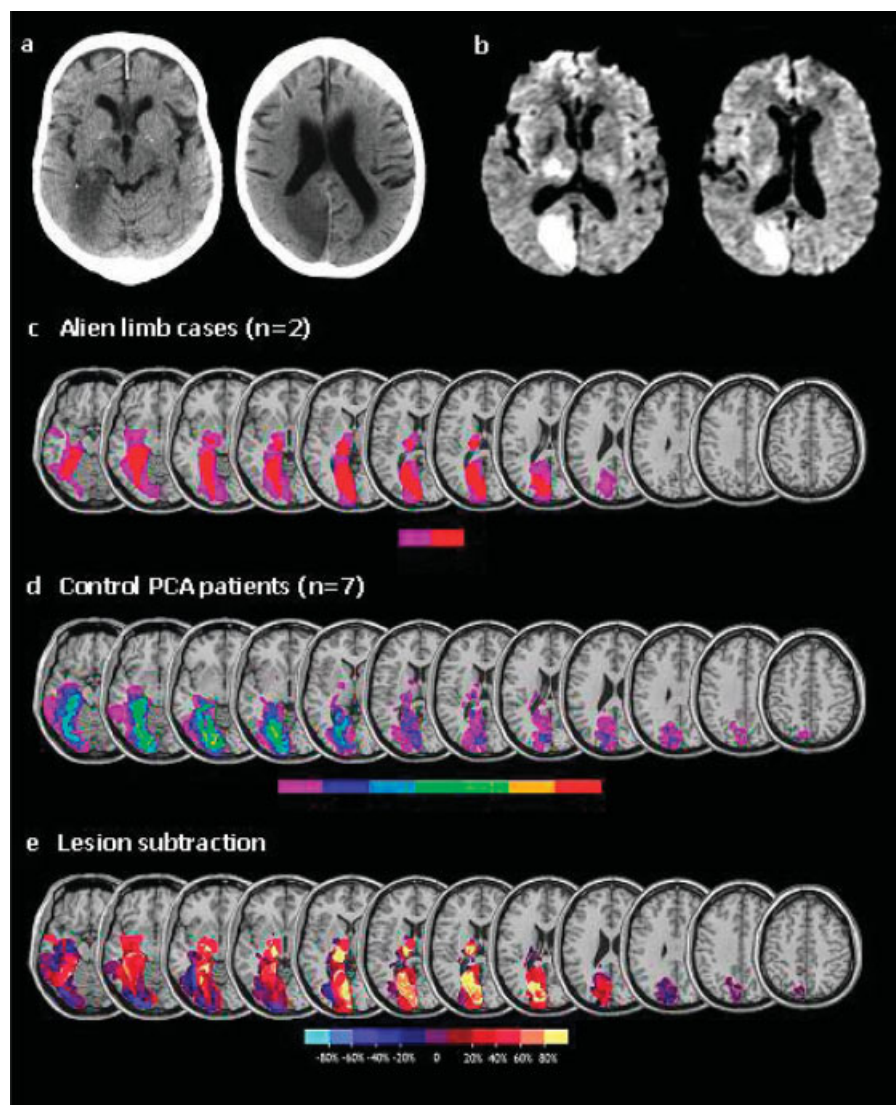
Axial section from CT showing infarction of the right occipital, inferior parietal and medial temporal lobe as well as the thalamus in Patient 1 (a) and the diffusion weighted MR scan revealing a similar lesion in Patient 2 (b). Diffusion weighted images are shown as the scan was performed in the first few days after the stroke and T2 images reveal less of the infarct. Lesion overlay of the two patients with alien limb (c), control PCA patients (d), and after subtraction of the 7 control patients with PCA stroke and no alien limb phenomenon (e). Lesions are plotted from routine clinical imaging onto MRICro template and the subtraction is performed using MRICro software (www.mricro.com). In (e), the area in yellow is the area affected in *both* alien limb patients and no more than one of the 7 control patients. Yellow areas include the occipital and inferior parietal cortex as well as the thalamus and to a lesser extent medial temporal. The color bar in (e) shows percentage involvement in the subtraction. In (c) and (d), the color bars show how many patients are affected in each areas ranging from 1 (purple) to 2 (red) in (c) and 7 (red) in (d). Z coordinates for the slices are: -18, -16, -11, -6, -3, 3, 13, 16, 20, 24, and 30 (from left to right).
